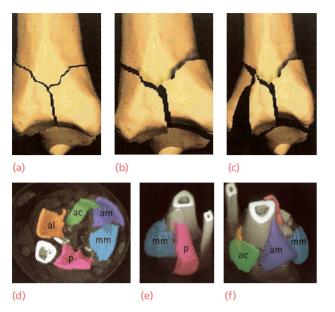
Pilon fractures – imaging These may be (a) undisplaced (type 1), (b) minimally displaced (type 2); (c) markedly displaced (type 3). CT (d) shows that there are usually five major tibial fragments: anterolateral (al), anterocentral (ac), anteromedial (am), the medial malleolus (mm) and the posterior fragment (p). These elements are better defined by 3D CT reconstruction.
